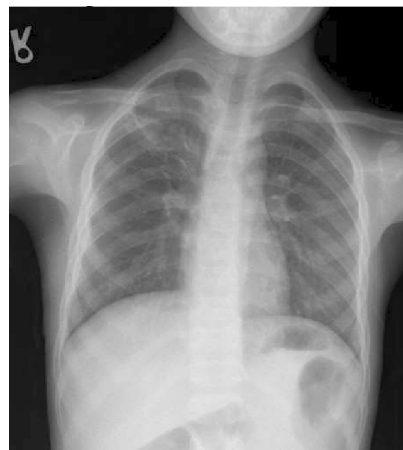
Postoperative day 1 radiograph. Shown is a fully expanded lung without pneumothorax. AP, anteroposterior.
